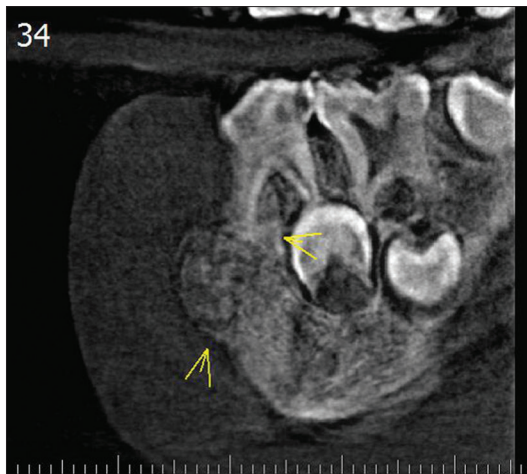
Cone beam computed tomography showing lesion surrounded by a peripheral radiolucency (yellow arrows)
